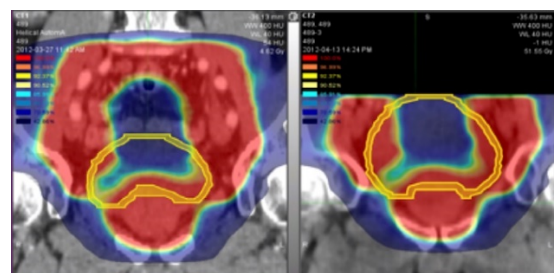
Upper Left Panel: characteristic patient with a smaller bladder volume in the plan CT (left figure) compared to one of the CBCT (right figure) acquired before a treatment session.
